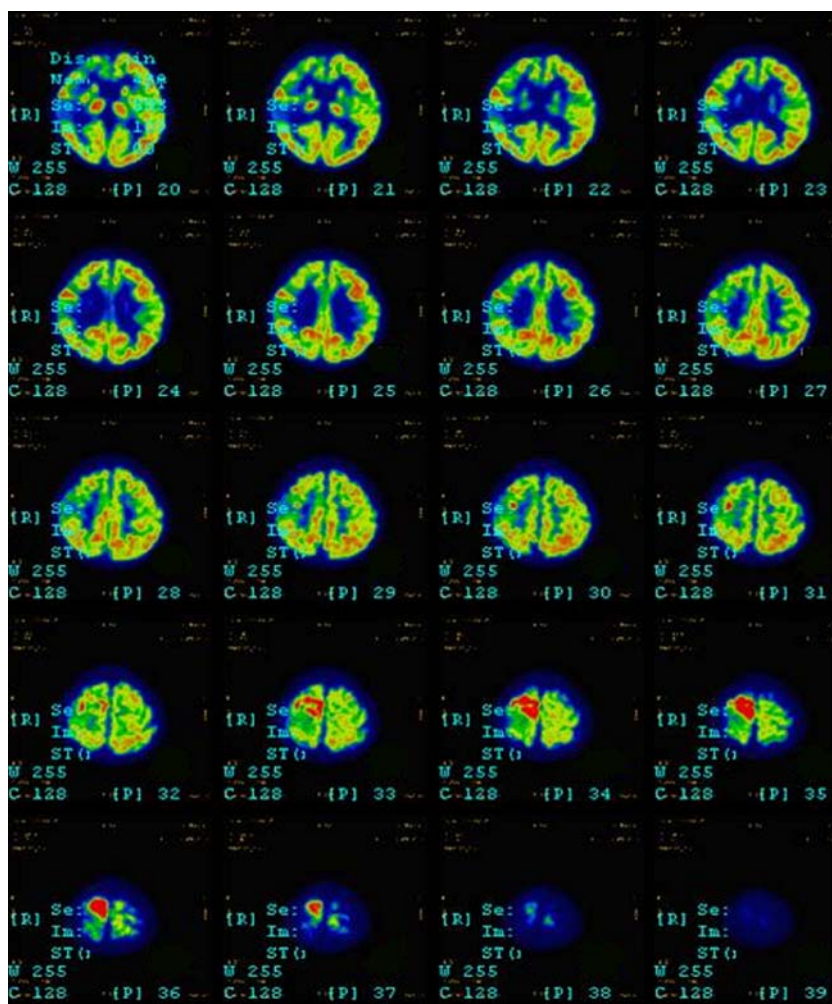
FDG-PET at age of 3 years showed extensive hypometabolism over right frontal-parietal-temporal region, and there was focal hypermetabolism over right parietal region, for which ictal focus was suspected
